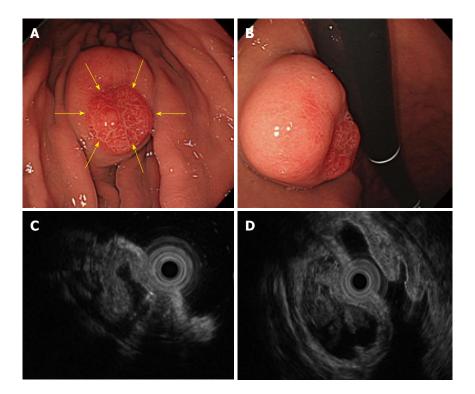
An submucosal tumor measuring 40 mm in diameter was found in the greater curvature of the middle body. A and B: The size of the submucosal tumor (SMT) had increased from the 20 mm in diameter that was reported 5 years before. In addition, a reddish erosive part 10 mm in diameter was found on the top of the SMT (yellow arrows). C and D: An endoscopic ultrasound revealed a heterogeneous tumor with small spotty cystic areas, a large anechoic cystic part, with papillary structures and 5 specific structural layers as its wall.
